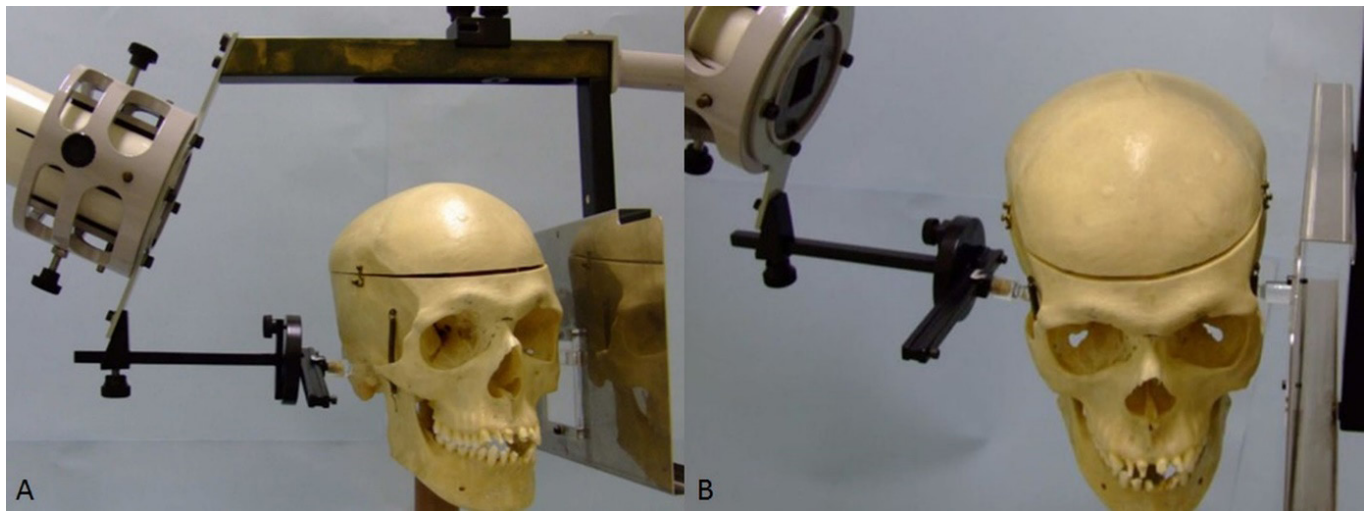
Transcranial radiograph. (A, B) Stabilization of the dried human skull using the Accurad-200 head holder
